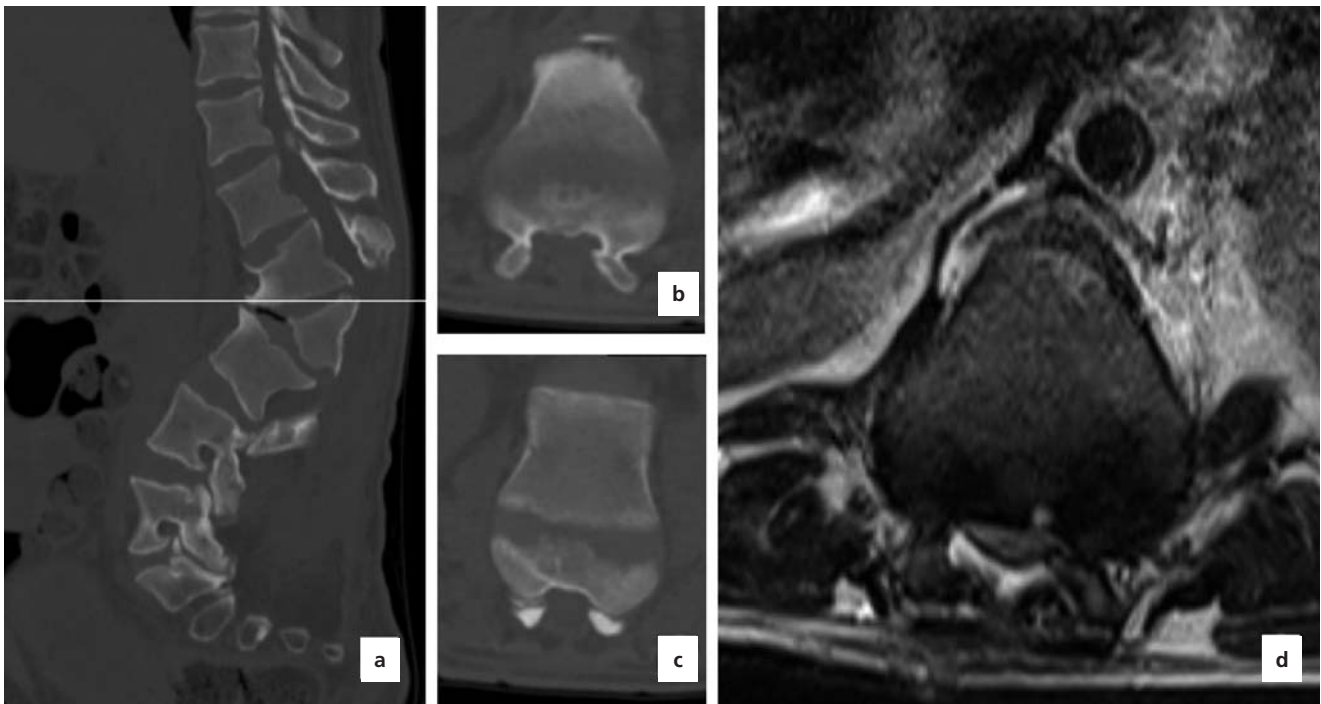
There are post operative changes in the spine. (a-c) Changes in sagittal and axial CT sections were observed after decompressive surgery. (d) Spinal canal enlargement at kyphosis level on axial MR section.
